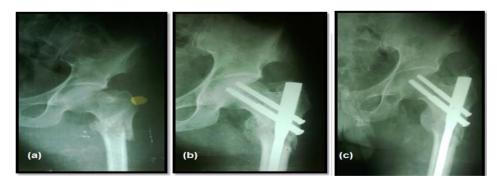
(a) Post traumatic X-ray left hip joint in AP view shows Type A-III fracture of proximal femur (b) Immediate post-operative X-ray (c) Final follow up X-ray with excellent results.
